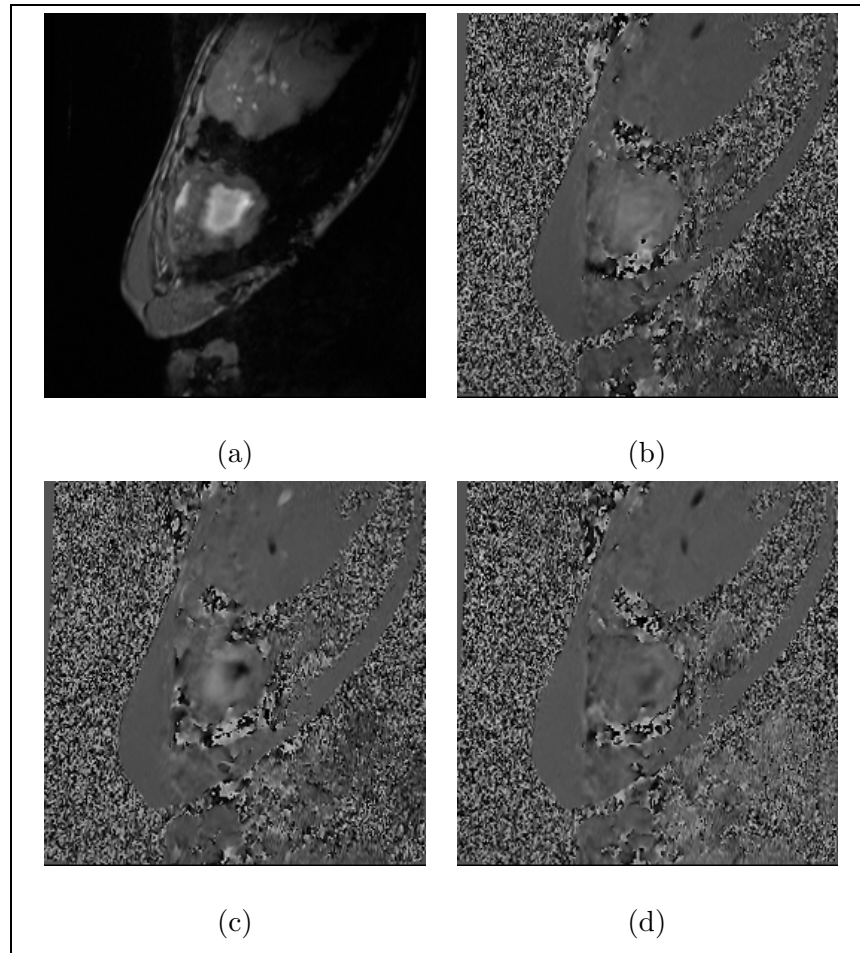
Phase contrast MR images. (a): the magnitude image; (b): the x direction velocity image; (c): the y direction velocity image; (d): the z direction velocity image. Please note that the velocity images show both positive and negative values of the velocity, with the dark colors representing negative values, the neutral grey for no motion, and bright colors for positive velocity values.
